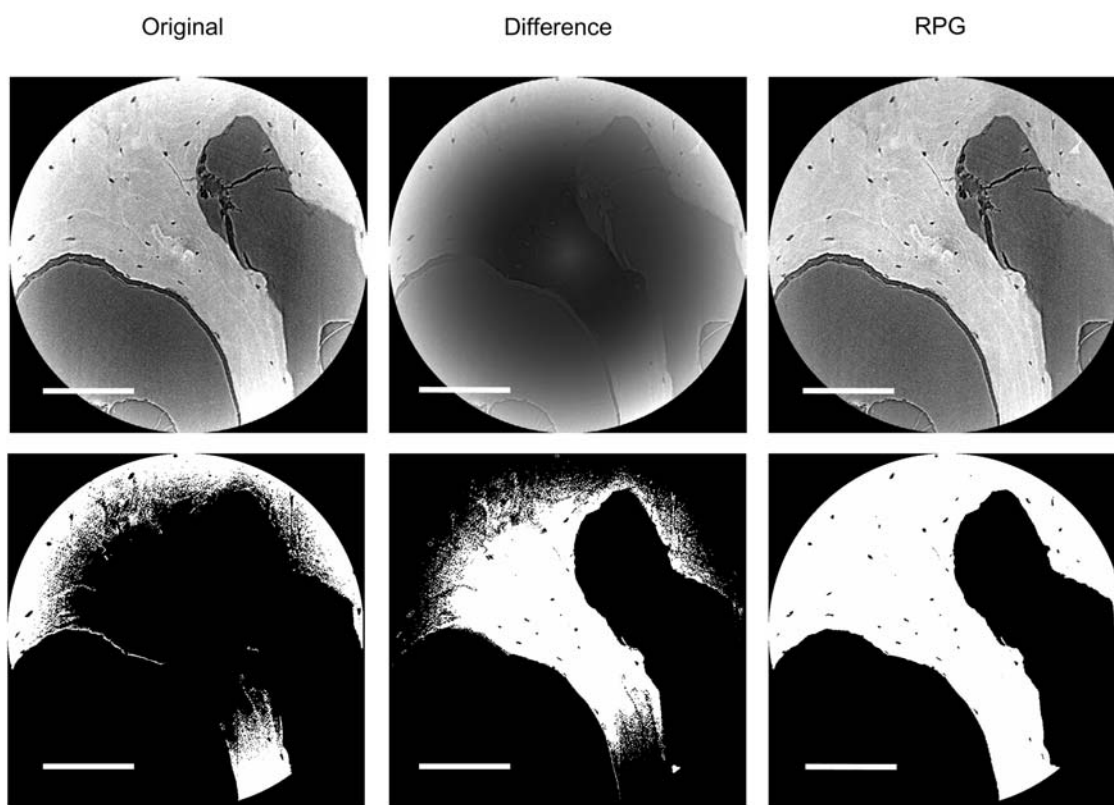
Radial gray value profile correction for local synchrotron radiation-based CT.
